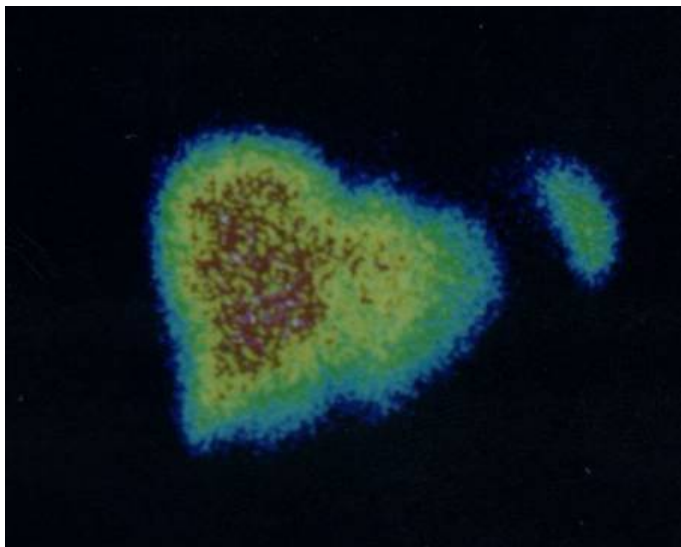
Static scintigraphy of liver with ^{99m}Tc -tehnefit (^{99m}Tc -labeled colloid). Increasing of the liver, decrease in ^{99m}Tc -labeled colloid accumulation, mainly in the field of the left lobe. Increase of ^{99m}Tc -labeled colloid capture by spleen (more than 10 %). Diffusion changes of liver parenchyma, typical for chronic hepatitis.
